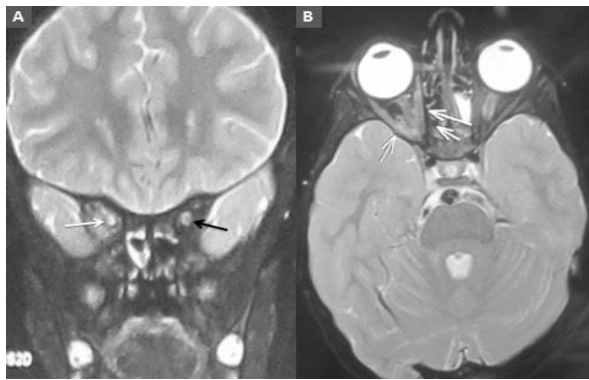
MRI Orbit and Brain without contrast showing A) Loss of target sign in Right eye (white arrow), positive target sign in Left eye (Black arrow) B) Intra-neural bright signals in right eye
